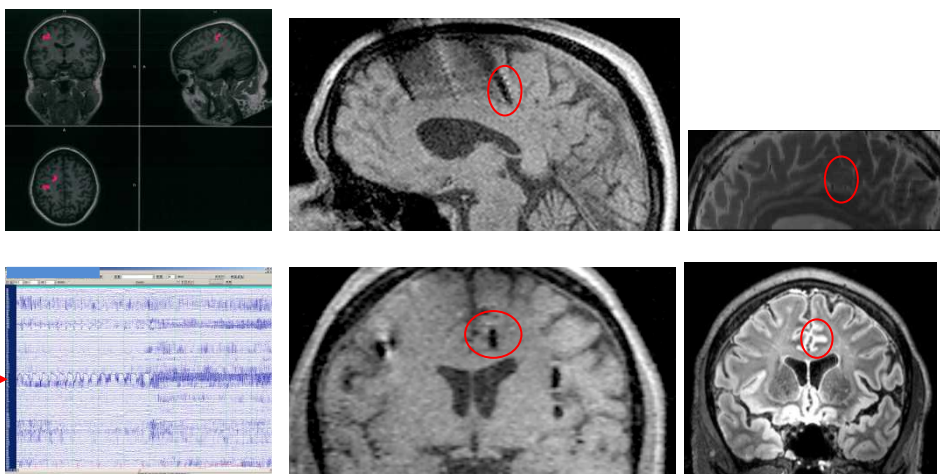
Re-evaluated region of epileptic focus as proved by SEEG that before SEEG were considered to be without anatomical abnormalities on visual inspection of the 7T MRI
